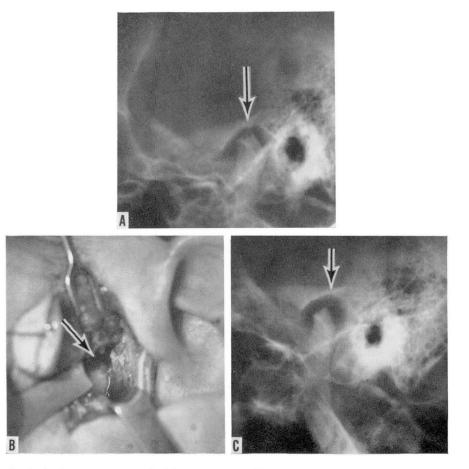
A, Roentgenogram of right temporomandibular joint. Note irregular condylar contour. B, Photograph of the condyle at the time of operation. Note irregular surface on condyle. C, Postoperative roentgenogram of the same patient showing improved joint space and condylar profile.
